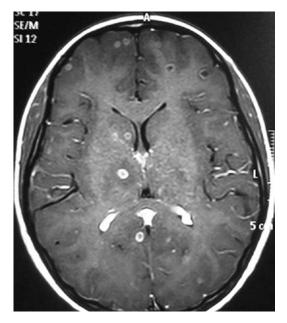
CT scan of the brain showing multiple ring lesions in neurocysticercosis
